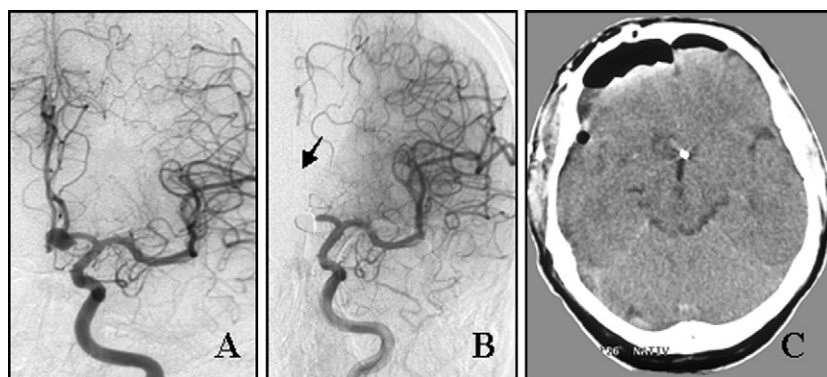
(A) Preembolization arteriogram demonstrating the left anterior communicating artery aneurysm. (B) Immediate postembolization arteriogram showing a dense packing of aneurysm and an occlusion of left A2. (C) Postoperative CT scan demonstrating no hemispheric infarction.
